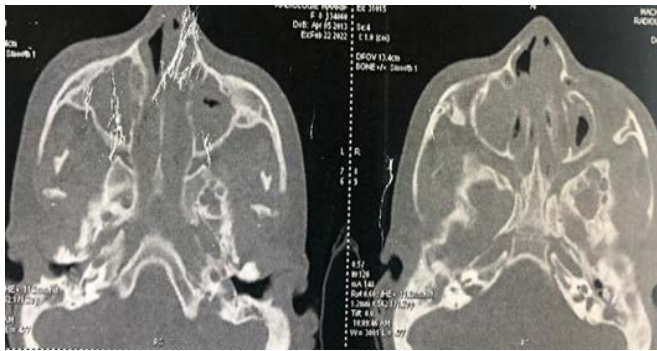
Axial- section CT scan of the nasal cavities showing total filling of the maxillary, ethmoidal, frontal and sphenoidal sinuses and nasal cavities.
